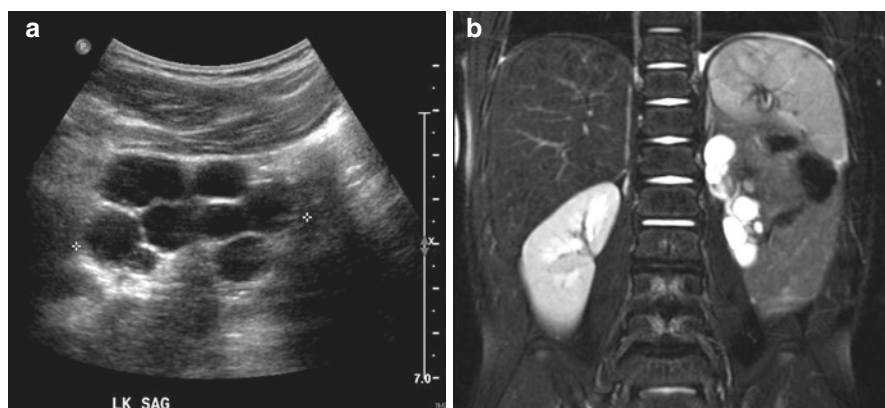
Left multicystic dysplastic kidney (MCDK). (a) Ultrasound and (b) MRI
